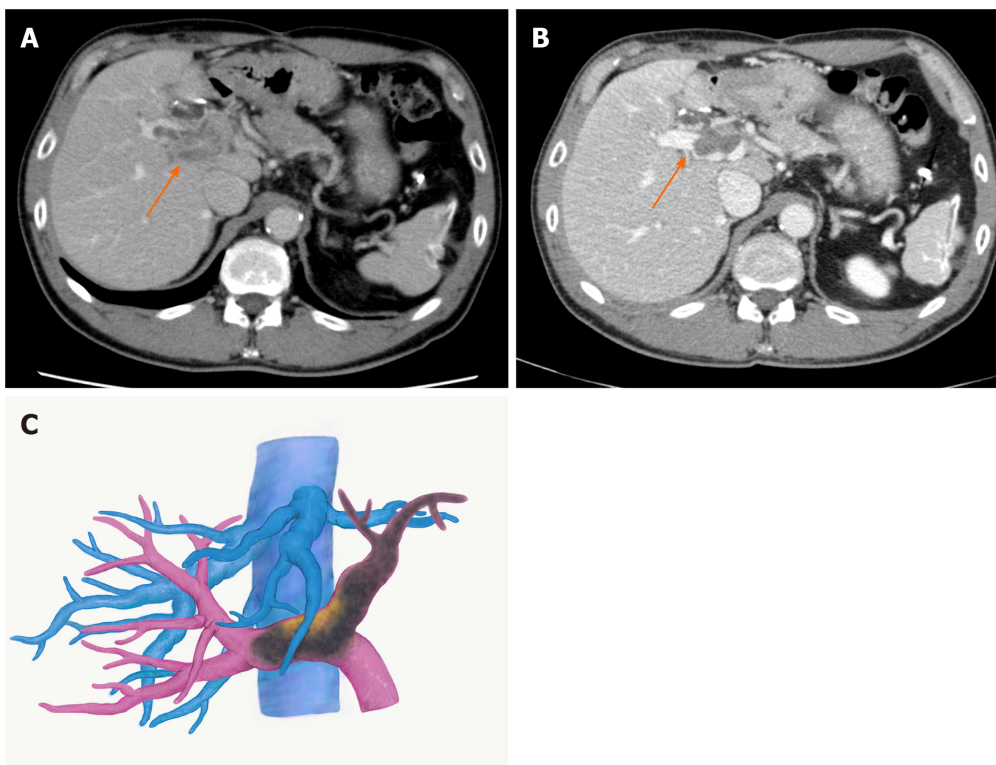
Images of hepatocellular carcinoma with portal vein tumour thrombus after lenvatinib treatment. A: Computed tomography image two weeks after the treatment. The portal vein tumour thrombus (PVTT) showed regression with partial disappearance of contrast enhancement; B: Computed tomography image three months after the treatment; C: Three-dimensional image three months after the treatment. The PVTT regressed to the contralateral first-order branch with loss of contrast enhancement. Arrows indicate PVTT.
